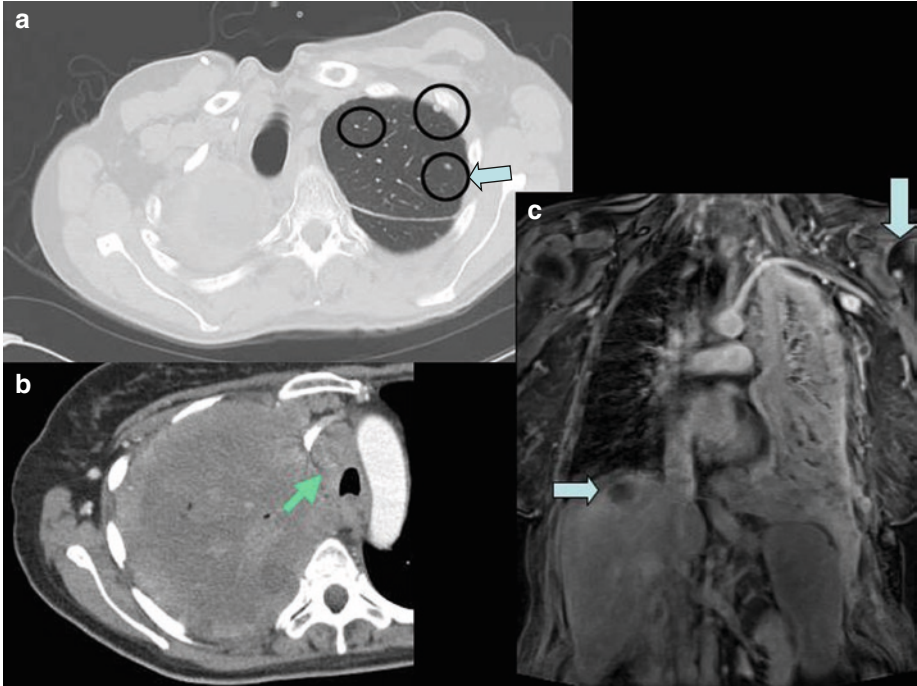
Axial CT images showing (a) contralateral pulmonary nodules, (b) mediastinal invasion and adenopathy (*arrow*), (c) coronal contrast-enhanced
